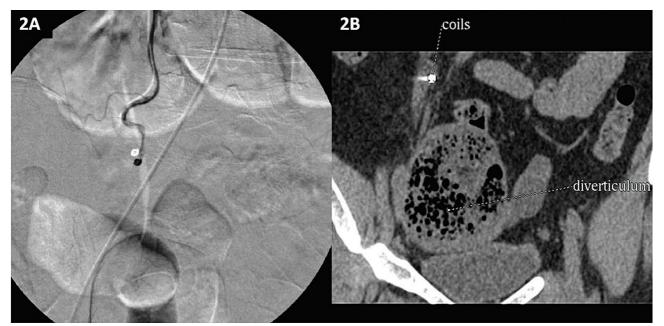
(A) Digital substraction angiography shows no distal flow. (B) Computed tomography scan of abdomen shows coils and sigmoid diverticulum.
